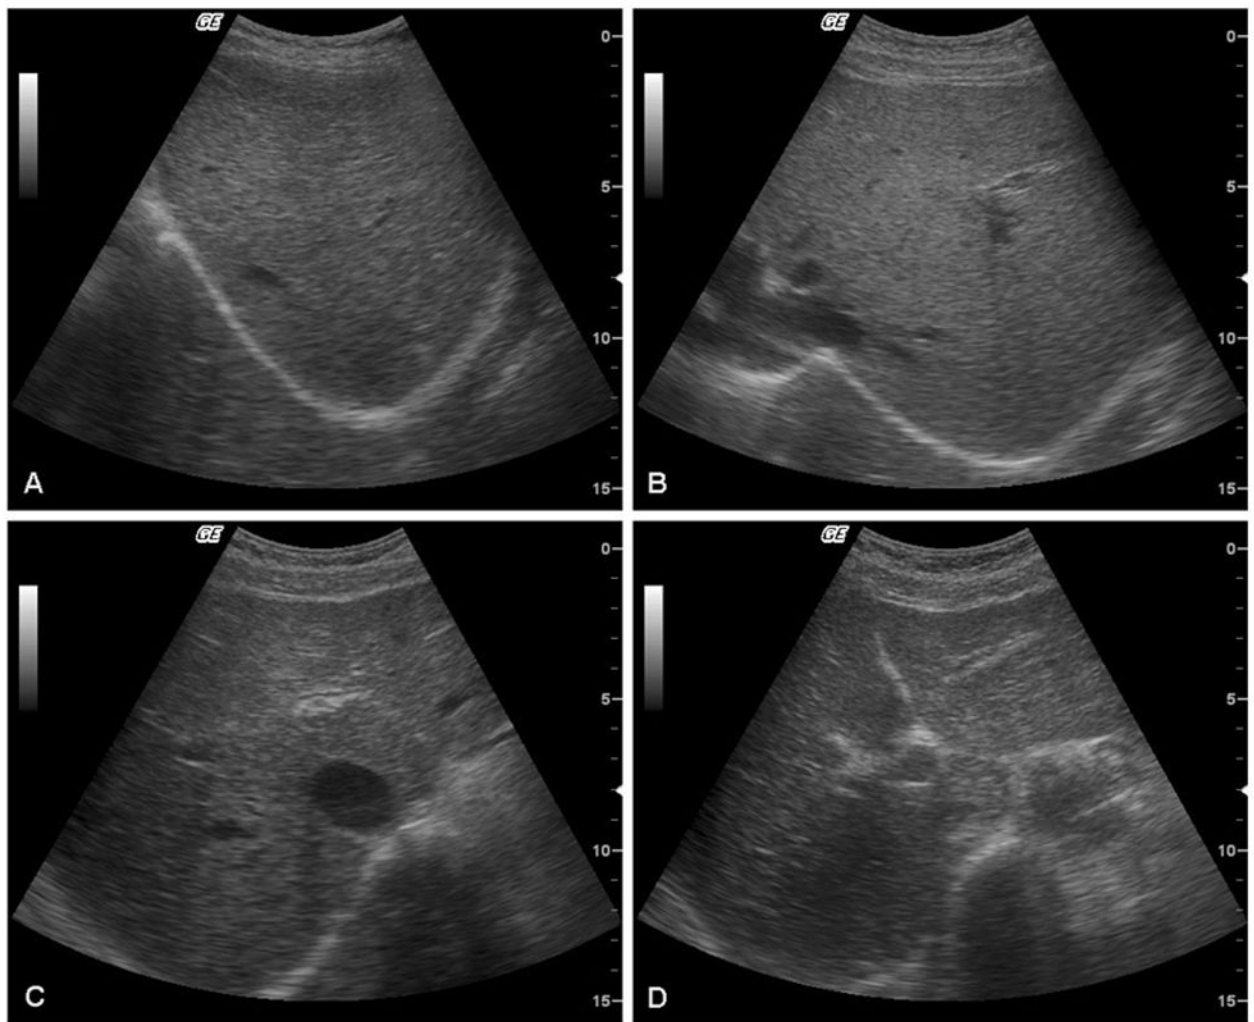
Representative ultrasonographs, revealing increasing periportal echoes and markedly enlarged gallbladder, in individuals categorized as grade 0 (panel A), 1+ (B), 2+ (C) and 3+ (D) periportal fibrosis. Individuals were classified as periductal fibrosis grade 0 when no echoes were observed (A); 1+ when echoes were observed in 1 segment of the liver (B); 2+ when echoes were observed in 2 or 3 segments of the liver (C); and, 3+ when echoes were observed in greater than 3 segments of the liver (D). Individuals were then dichotomized into “Non-advanced fibrosis” or “control” if the ultrasonography (US) grade was 0 or 1 and “Advanced Fibrosis” or “case” if the US grade was 2 or 3.
